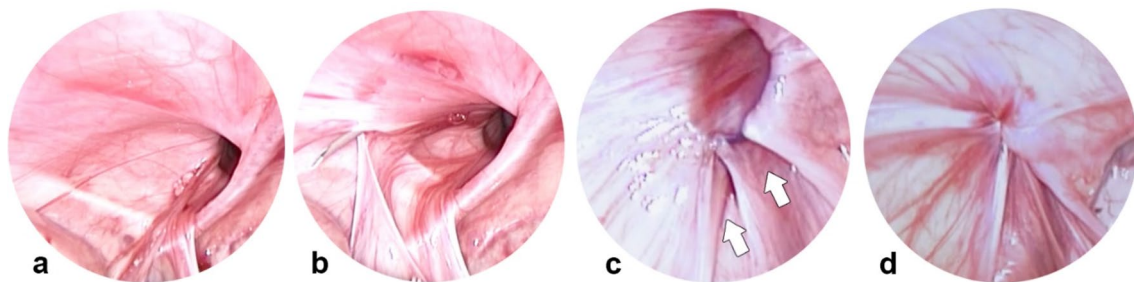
FLAIR for large left inguinal hernia with VD and TV far apart from each other. a Large left PPV with many peritoneal folds between the VD and TV. b Peritoneum is stretched to show the distance between the VD and TV. c Suture skips over the VD and TV individually. The white arrows indicate the excluded peritoneum covering
